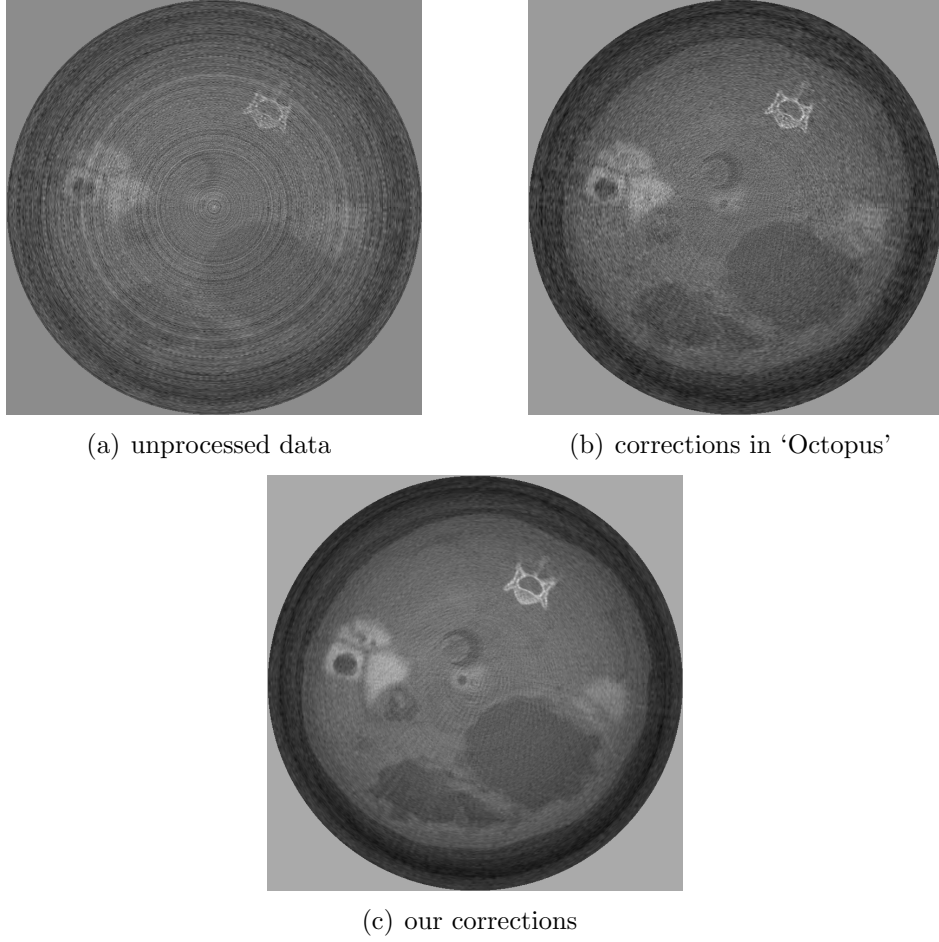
Resulting CT slices for different methods of image processing.
